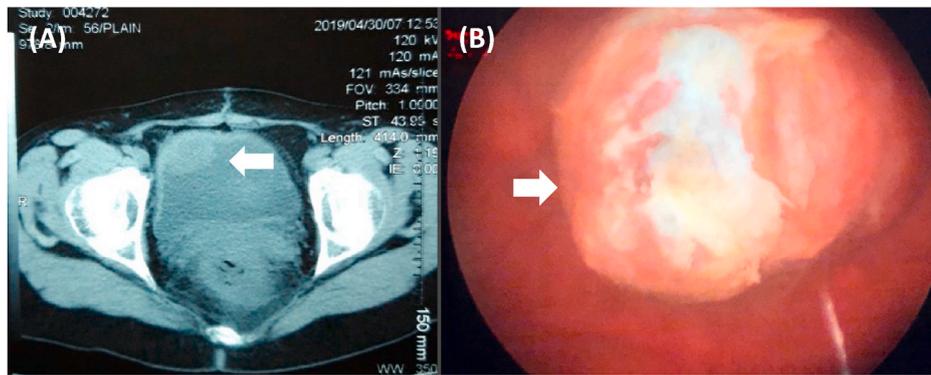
Preoperative and intraoperative images of the bladder mass (indicated by arrow). A.) Computed tomography (CT) scan, B.) Cystoscopic appearance.
